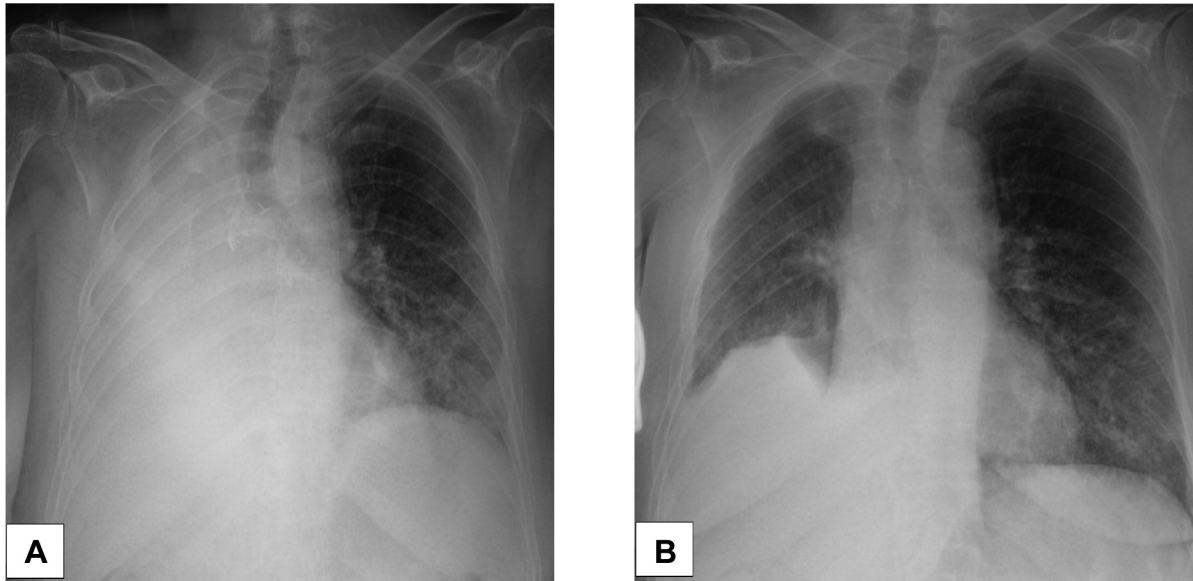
Images of the chest of the patient who underwent palliative radiotherapy for malignant airway obstruction. A) Pre-treatment chest X-ray. B) Post-treatment chest X-ray.
